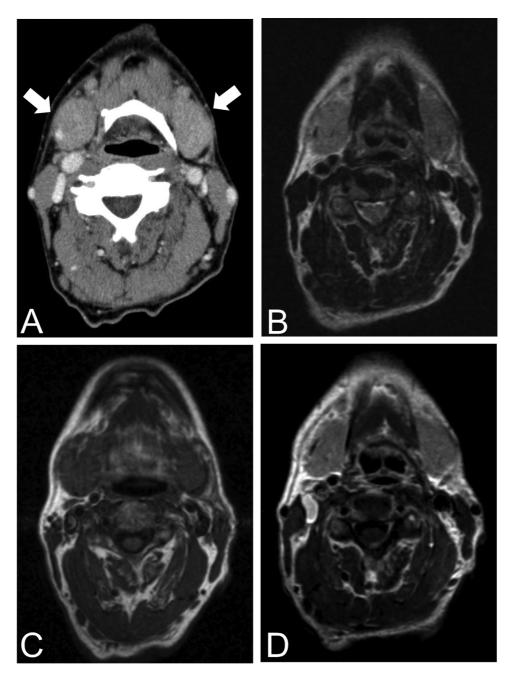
Imaging findings before removal of the submandibular gland. (A) Contrast computed tomography scan. Arrows indicate swelling of the bilateral submandibular glands. (B-D) Magnetic resonance (MR) images showing enlargement of the bilateral submandibular gland, with homogeneous mild hyperintensity seen on T2-weighted images (B), homogeneous mild to moderate hypointensity seen on T1-weighted images (C), and mild homogeneous enhancement seen on contrast-enhanced MR images (D).
